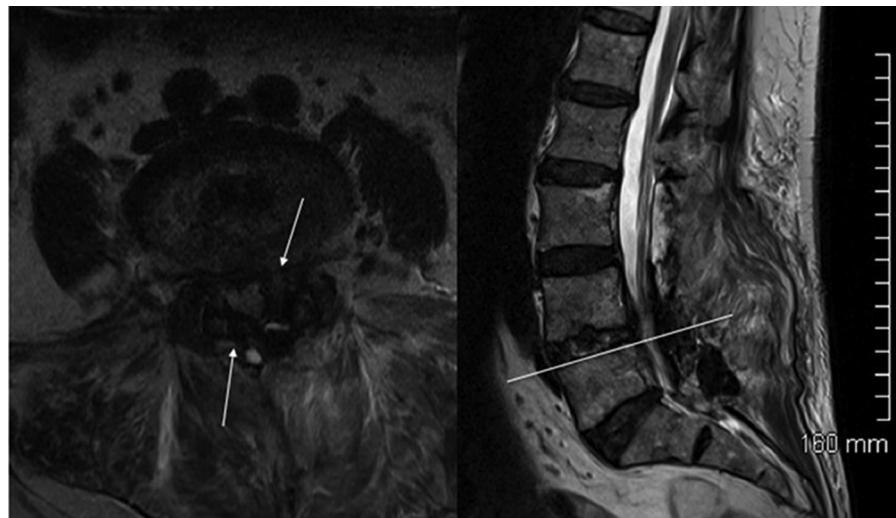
T2-weighted magnetic resonance imaging scan showing cauda equina compression to be related to a peripheral epidural mass yielding a frank hypointense signal (arrows), which was found to be a “glue-oma” during subsequent surgery.
